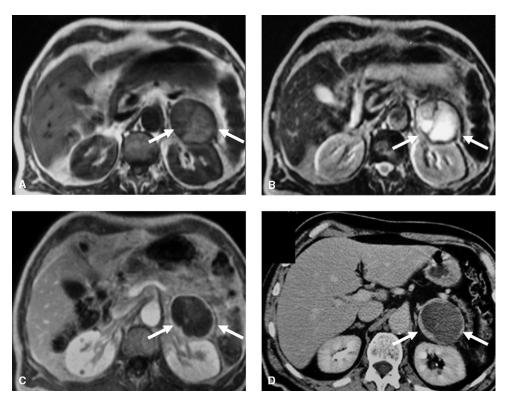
Left adrenal pheochromocytoma. Unenhanced T1-weighted (A), T2-weighted (B), and enhanced T1-weighted (C) MRI axial acquisitions; enhanced CT study in late venous phase (D). A large, oval mass with regular margins (white arrows) is shown (A–D). Previous internal subacute hemorrhage explains medium–high signal intensity on T1-weighted acquisition (white arrowheads) due to the presence of meta-hemoglobin, a natural paramagnetic agent. The colliquative, hydrated necrosis consequent to the hemorrhage is also demonstrated by the high signal intensity on T2-weighted image (B), by the absence of internal enhancement after gadolinium chelates CA administration (C), and by the same pattern on enhanced CT study (D).
